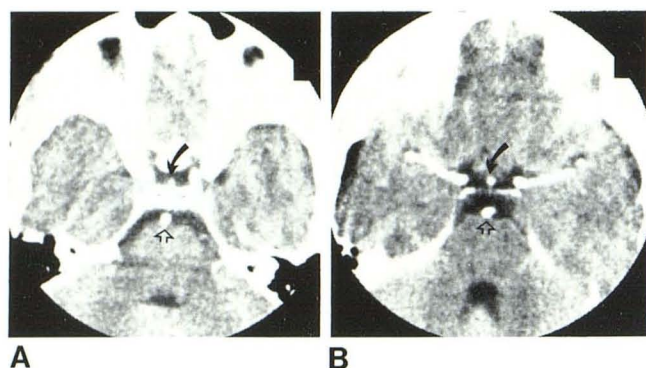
Two contiguous axial CT sections. Normal pituitary stalk (solid arrow) and basilar artery (open arrow). In A, stalk is seen at level of dorsum; in B, stalk is slightly above level of dorsum and just posterior to optic chiasm.
